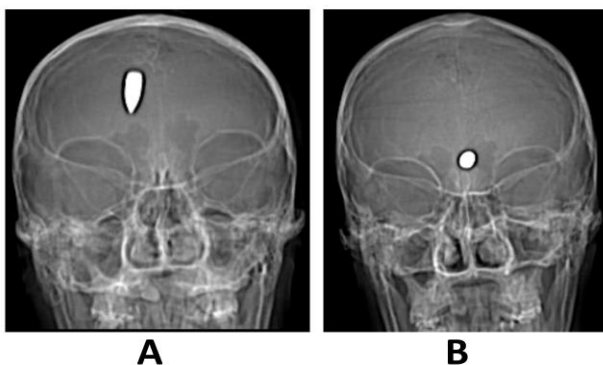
Head x-ray in coronal view, A: before bullet migration, B: after bullet migration.
